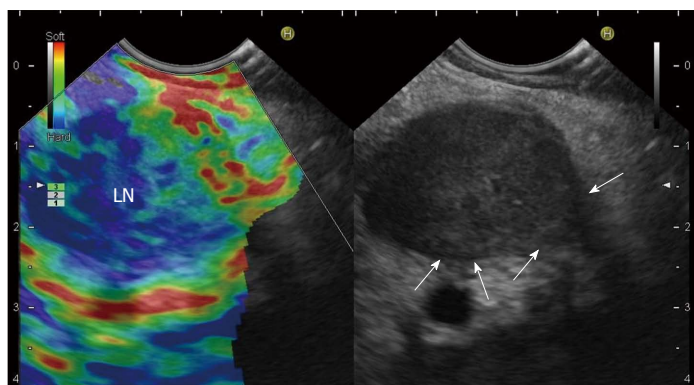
Malignant Lymph nodes on endoscopic ultrasound elastography. A malignant lymph node is revealed as predominantly hard (blue). Arrows indicate infiltration. LN: Lymph node.
